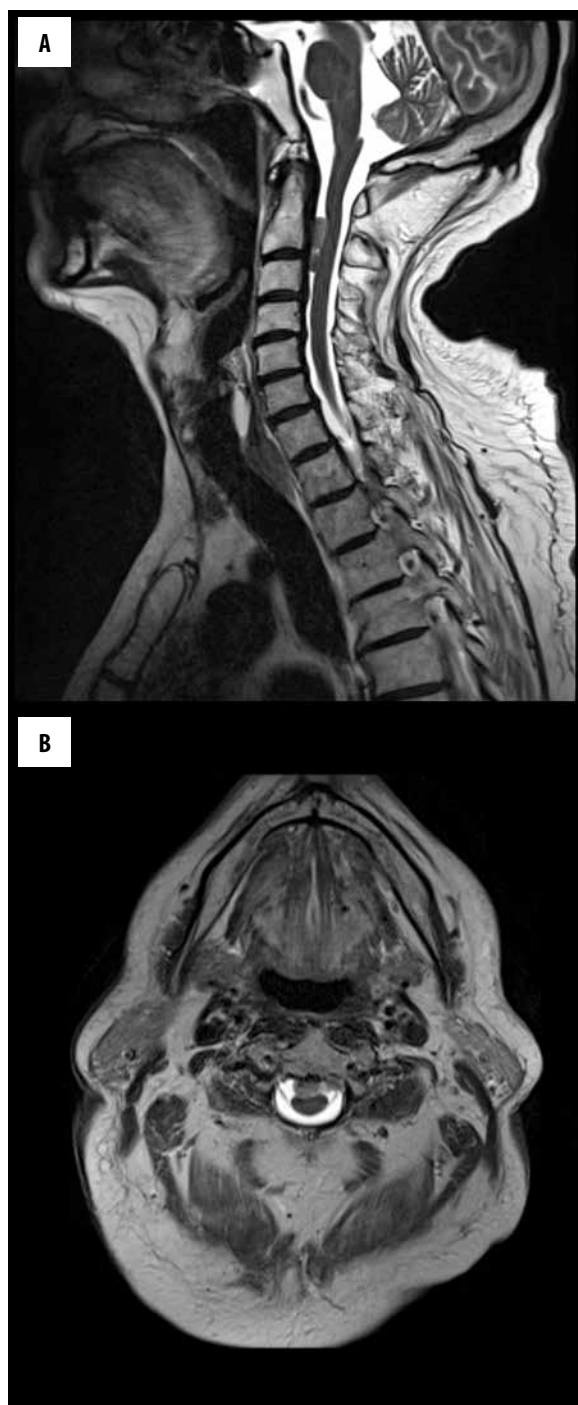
MRI of the cervical spine: Sagittal (A) and transverse (B) T2-weighted images of the cervical spine demonstrates two intradural extramedullary masses at the level of C2–C3 abutting the ventral aspect of the spinal cord. (C) Sagittal contrast-enhanced T1-weighted image shows an intense contrast enhancement of the masses, consistent with metastatic disease.
